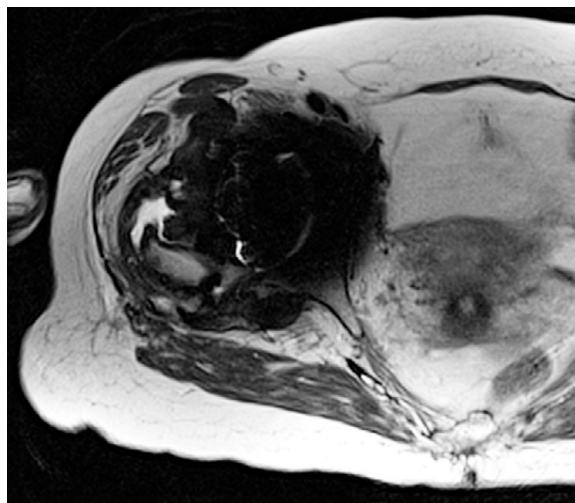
MRI pelvis axial T2
